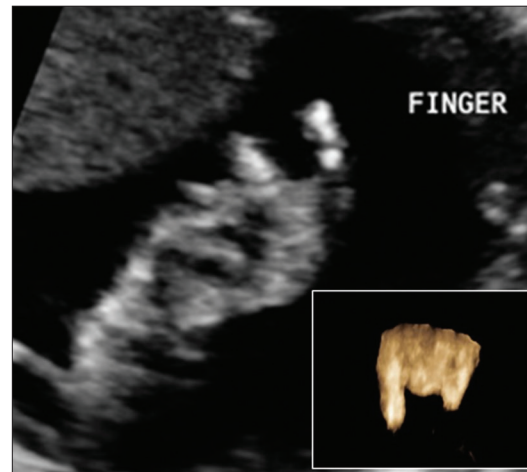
Ultrasound images (two-dimensional and three-dimensional) showing camptodactyly (fixed pointing of index and little fingers) in a fetus with Stuve–Wiedemann syndrome
